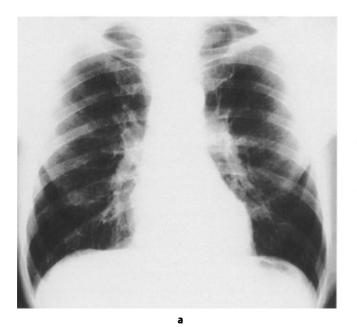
A 59 year old male patient smoking 20 cigarettes per day for 40 years. Radiograph (a), and CT (b), show the predominance of a triad of signs such as peribronchial thickening, interlobar thickening, and ground-glass attenuation.
